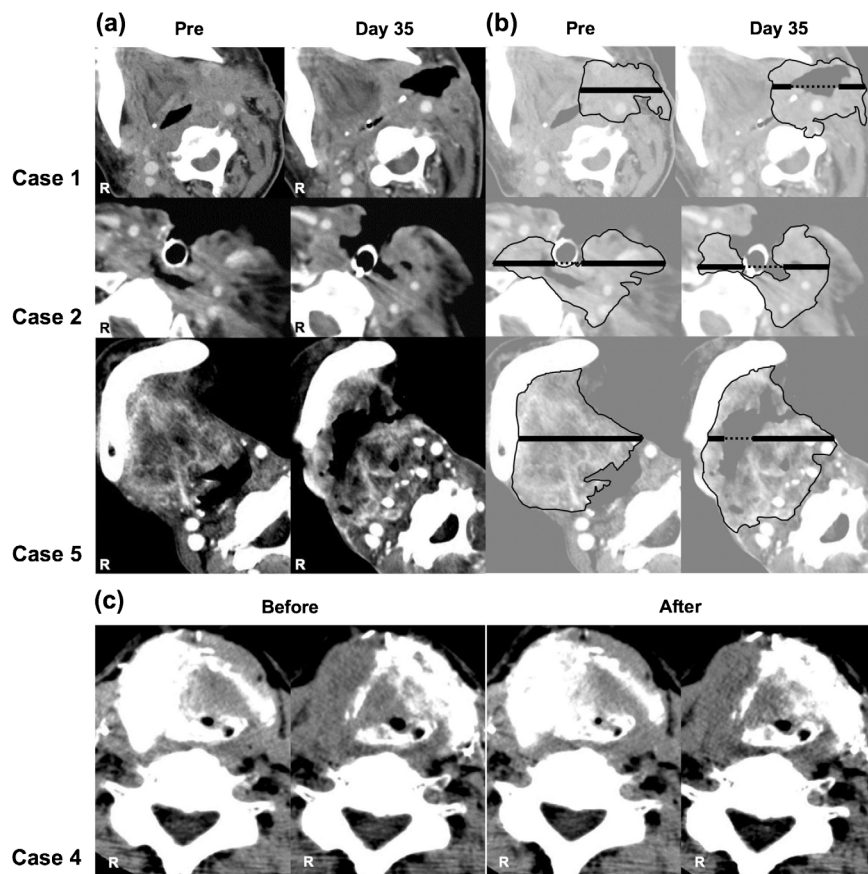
Computed tomography (CT) images. (a) The real CT images of three partial response cases are shown. (b) The cancer region is surrounded by a thin line and the longest diameter is indicated by a bold line. (c) Perfusion CT images before and after the intra-arterial infusion of the activated $V\alpha 24$ natural killer T cells are shown (case 4).
